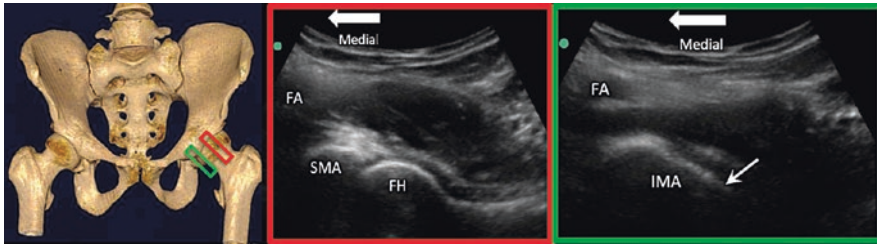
Left figure showed the position of the ultrasound probe in both positions (red and green rectangles). The middle and right figures were the corresponding sonographic images in red and green rectangles, respectively. SMA, superomedial acetabulum; IMA, inferomedial acetabulum; FA, femoral artery; FH, femoral head; arrow, target of the obturator articular branches. (Reprinted with permission from Philip Peng Educational Series)
